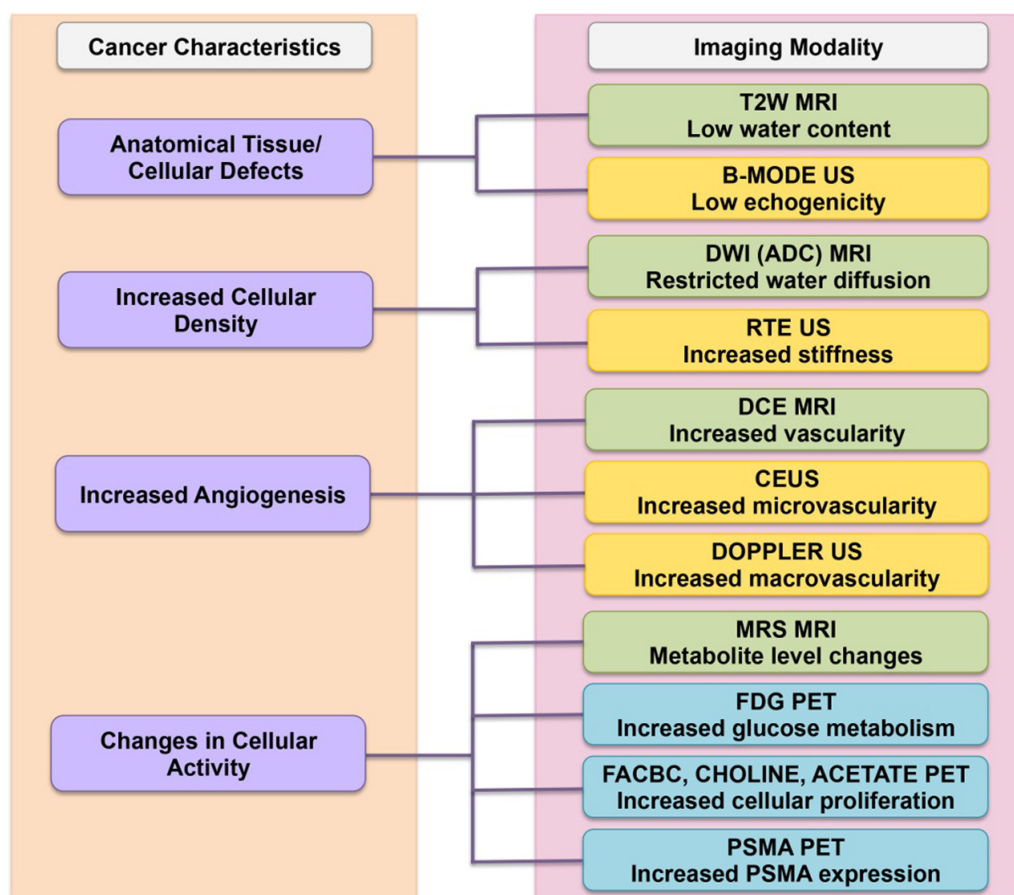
Correspondence of imaging modality to cancer characteristics. The left column shows the biological cancer characteristics and their correspondence to the choice of imaging modalities that exploit it are shown on the right. Specific imaging techniques are color coded based on the underlying major modality: US (yellow), MRI (green), and PET (blue).
